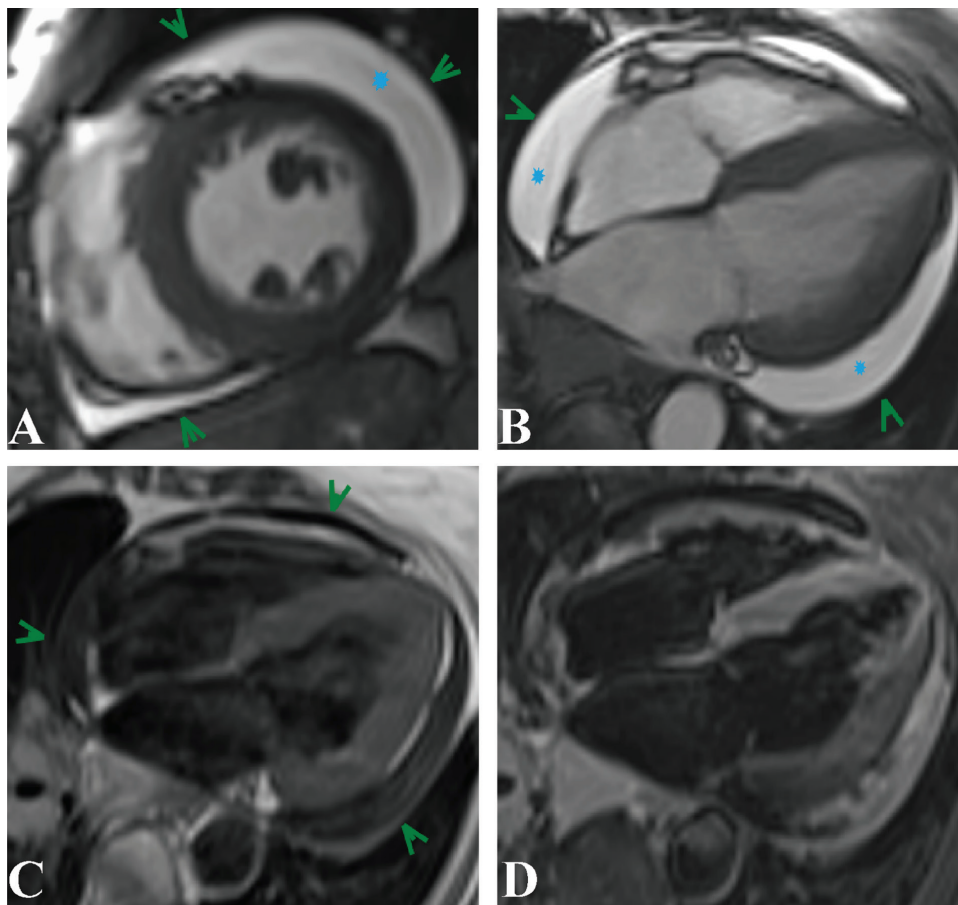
Cardiac magnetic resonance of a 32-year-old patient with systemic sclerosis with circumferential pericardial effusion visible from short-axis (A) and long-axis images (B) of balanced SSFP (*bleu arrowheads*); T2-weighted short-tau inversion-recovery spin-echo (C); T1-weighted spin-echo (D). The pericardial effusion has an inhomogeneous spread, especially on T2-weighted short-tau inversion-recovery spin-echo CMR. Abbreviations: b-SSFP, balanced steady-state free precision; CMR, cardiac magnetic resonance imaging.
